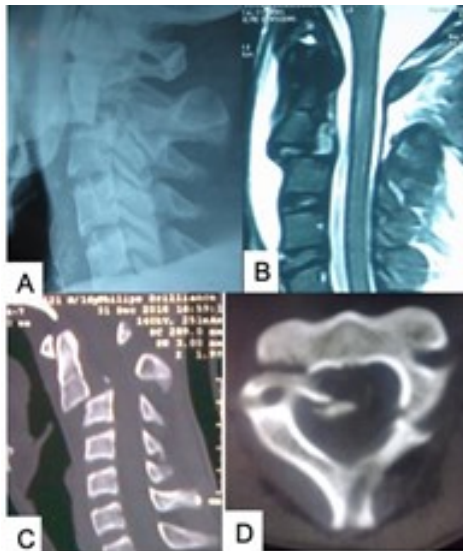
(A) X-ray, (B) MRI, and (C,D) CT scan of cervical spine showing hangman's fracture. Source: Figure by authors.
